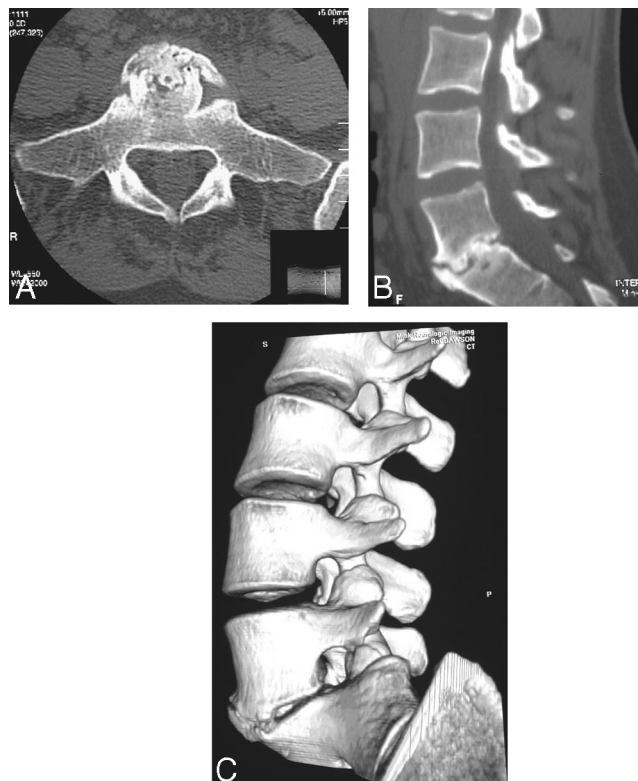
CT of FRA use with rhBMP-2 (in this case at 6 months) reveals extensive bone graft resorption and disintegration. Axial (A) and sagittal (B) cuts, and a 3-dimensional reconstruction (C) are shown.
